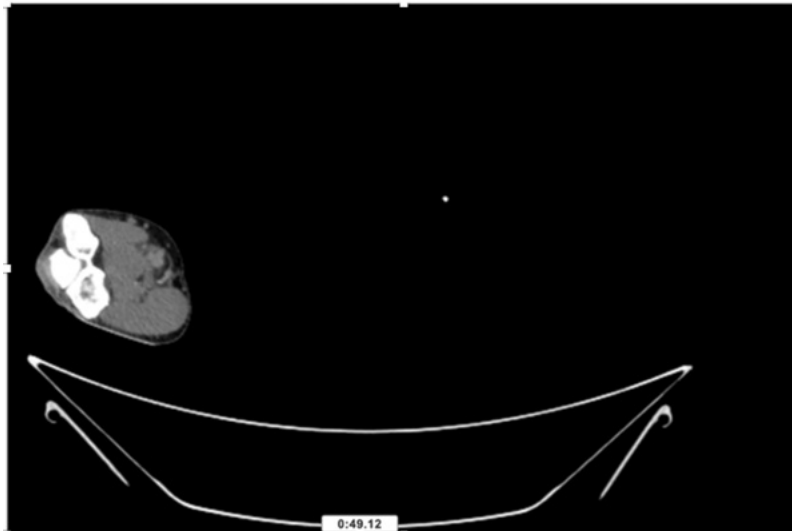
CT Angiogram at elbow joint showing totally occluded right brachial artery.
